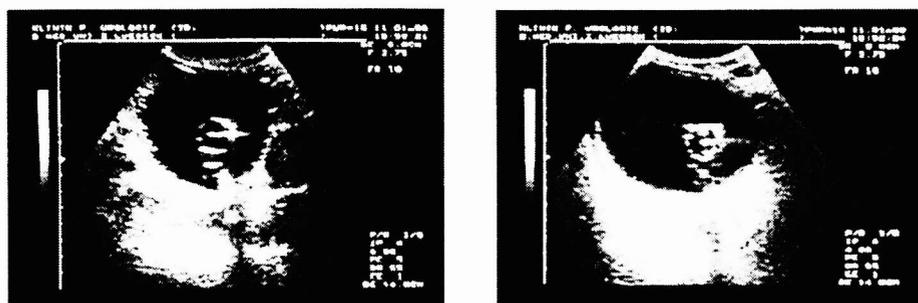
Ultrasound control of the bladder
